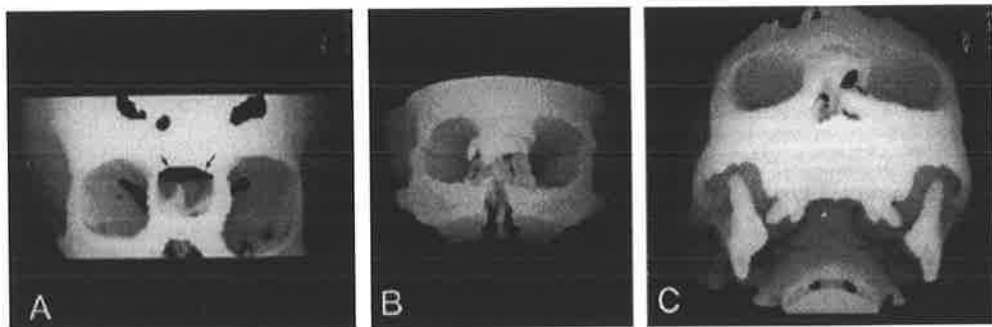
Three-dimensional CT reconstructions of frontoethmoidal cephaloceles, showing the exit foramina (arrows) in the facial skeleton: A nasofrontal; B nasoethmoidal; C naso-orbital.
